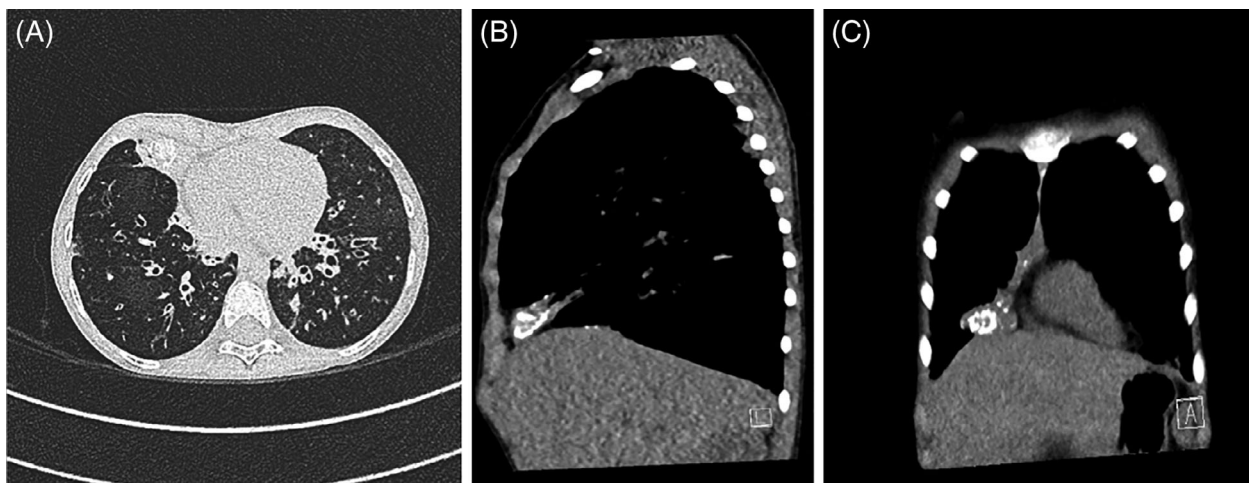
(A) Chest computed tomography (CT) axial cut showing calcification in the right middle zone containing air fluid level. (B) Chest CT coronal showing calcification in the right middle zone. (C) Chest CT sagittal showing calcification
